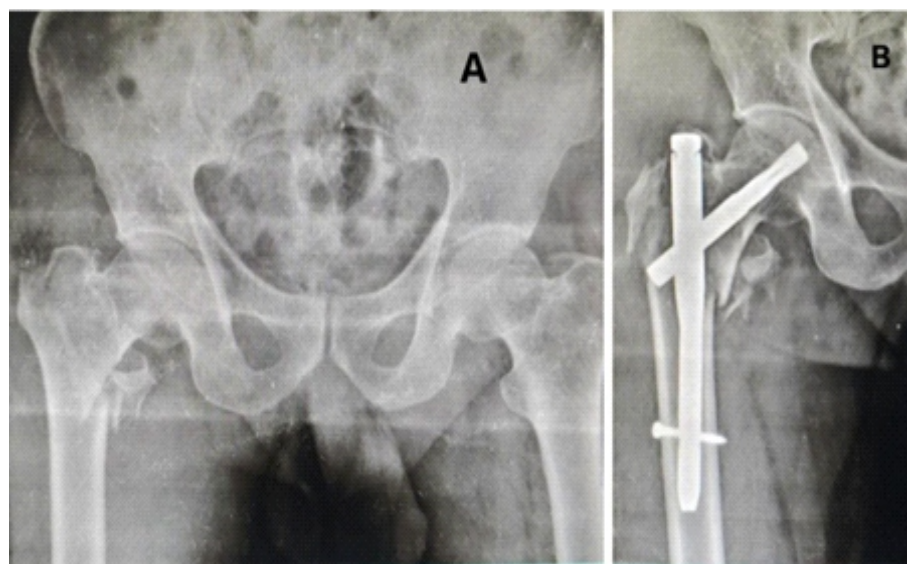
(a) Pre-operative anterior-posterior (A-P) view X-ray showing TYPE 31-A2.2 pertrochanteric femur fracture of the right side. (b) Post-operative A-P view X-ray showing pertrochanteric femur fracture fixed with short proximal femur nail.
